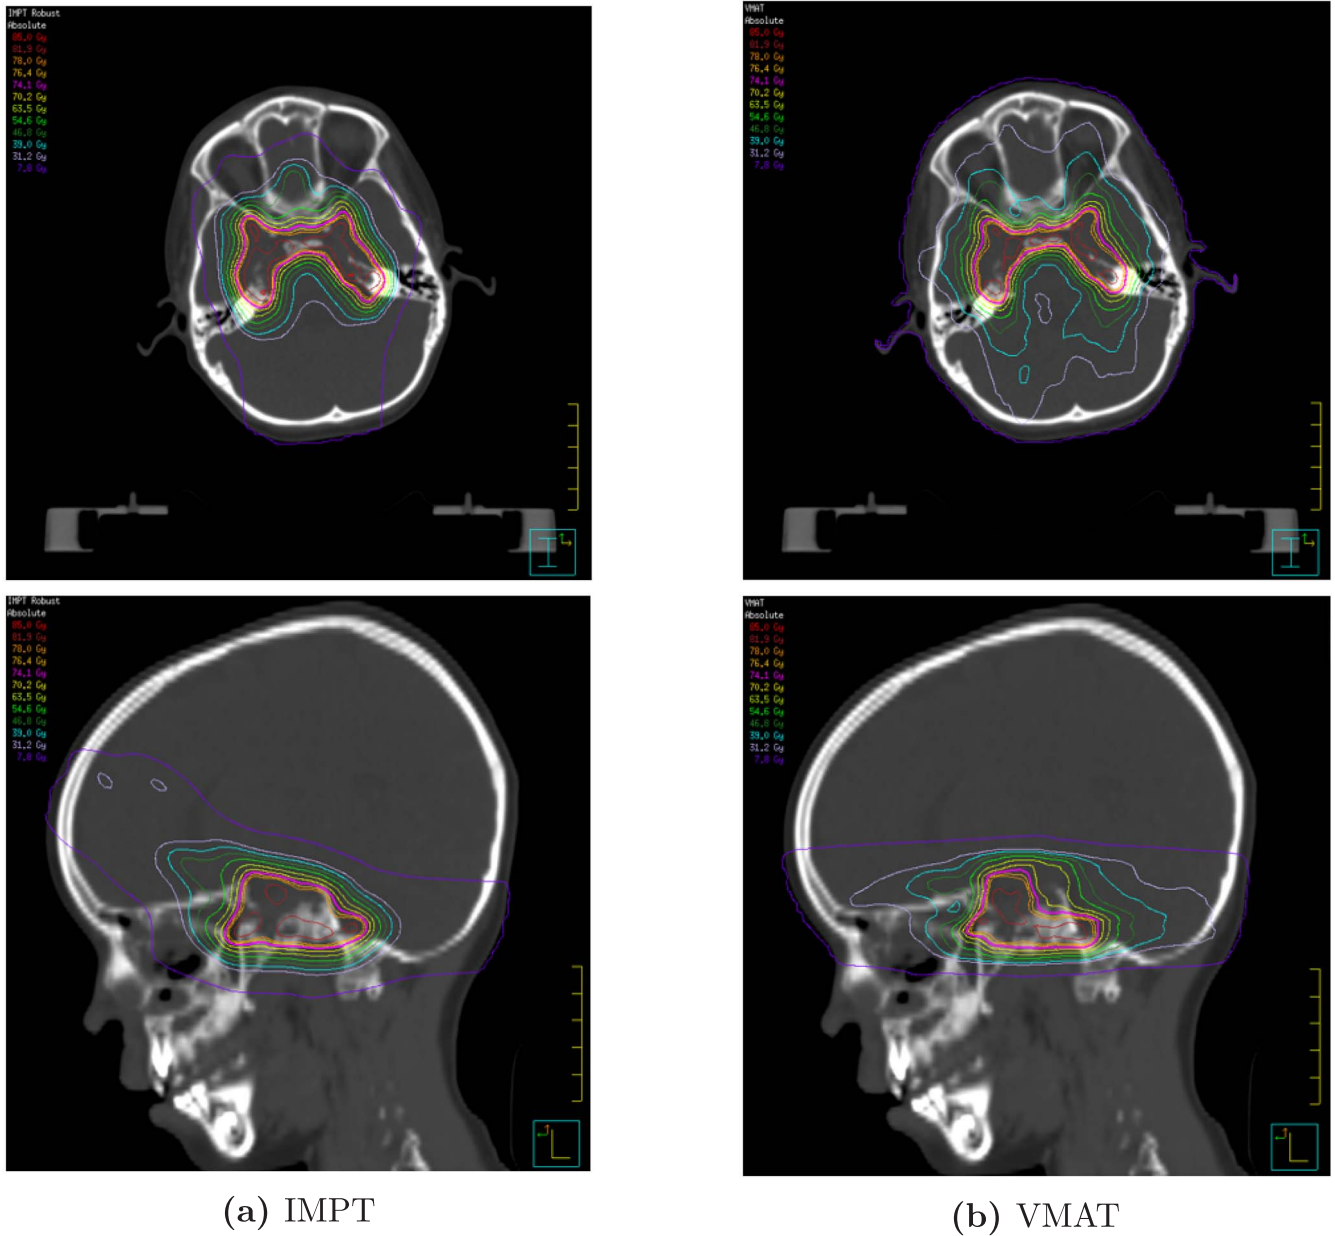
The CT scan of the patient with the isodose contours for each treatment plan.
